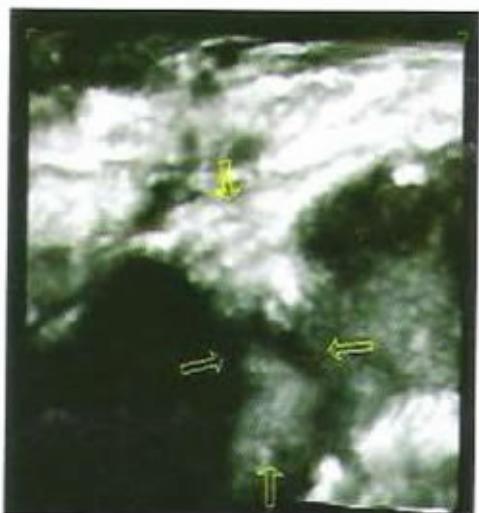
SUB-TOTAL RUPTURE TO THE SPRING-LIGAMENT VISUALIZED WITH MR ( A ) AND WITH 3-D ULTRASOUND ( B ).
